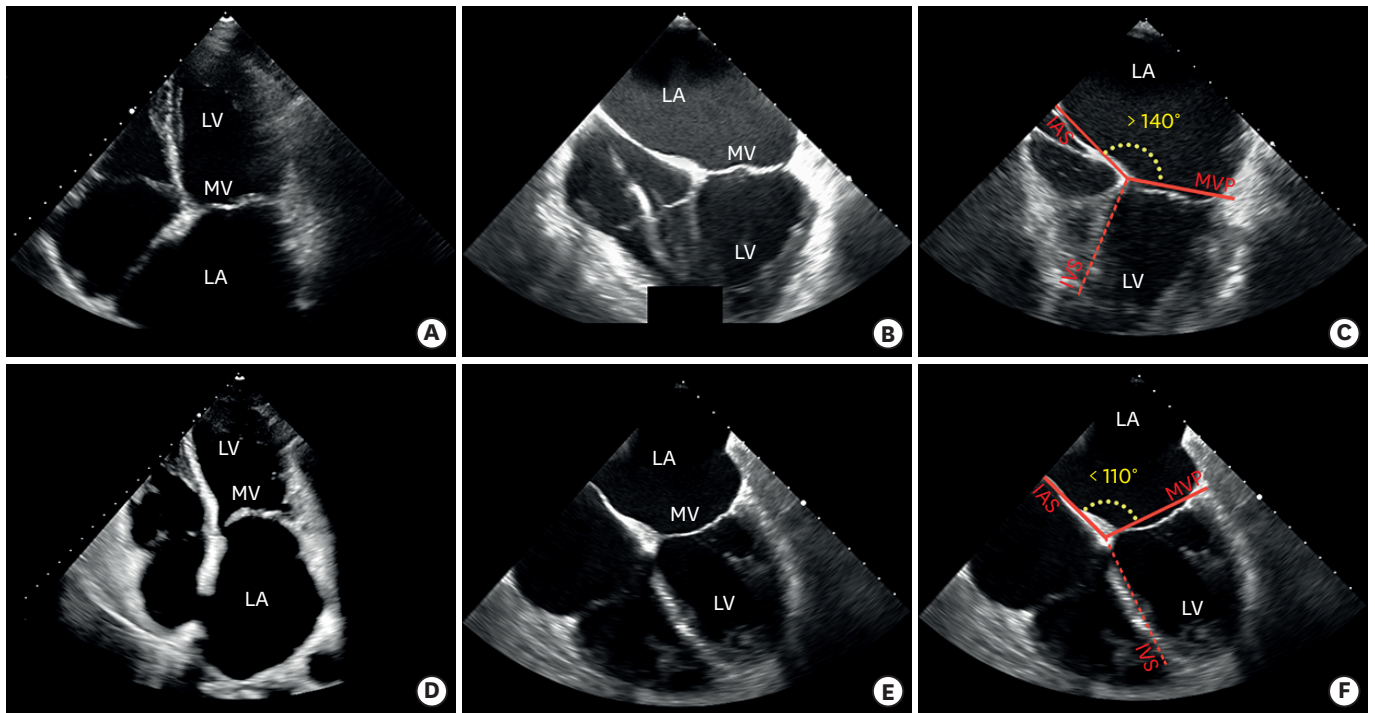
Comparing cases of patients with giant LA and abnormal (A-C) or normal (D-F) angle between IAS and MVP. Transthoracic echocardiography: apical 4 chamber view (A,D). Transoesophageal echocardiography: 4 chamber view (B,E). Transoesophageal echocardiography, 4 chamber view: *post hoc* angle measurement (C,F).
